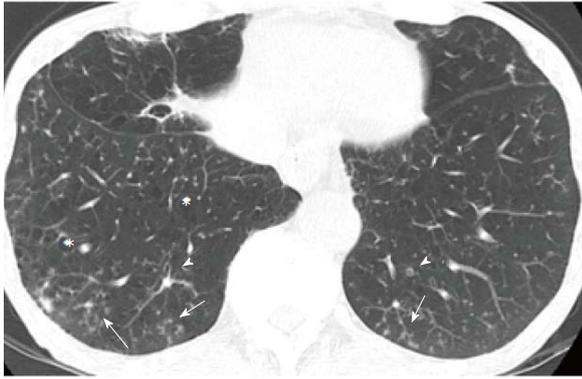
Chronic transbronchial infection (diffuse aspiration bronchiolitis) in a man in his 70s. This patient had a history of esophageal carcinoma and associated repeated aspiration. Thin-section computed tomography at the level of lung base shows centrilobular nodules (arrows) with bronchiectasis (arrow heads). Low attenuation areas suggestive of pulmonary emphysema are also present (*).
